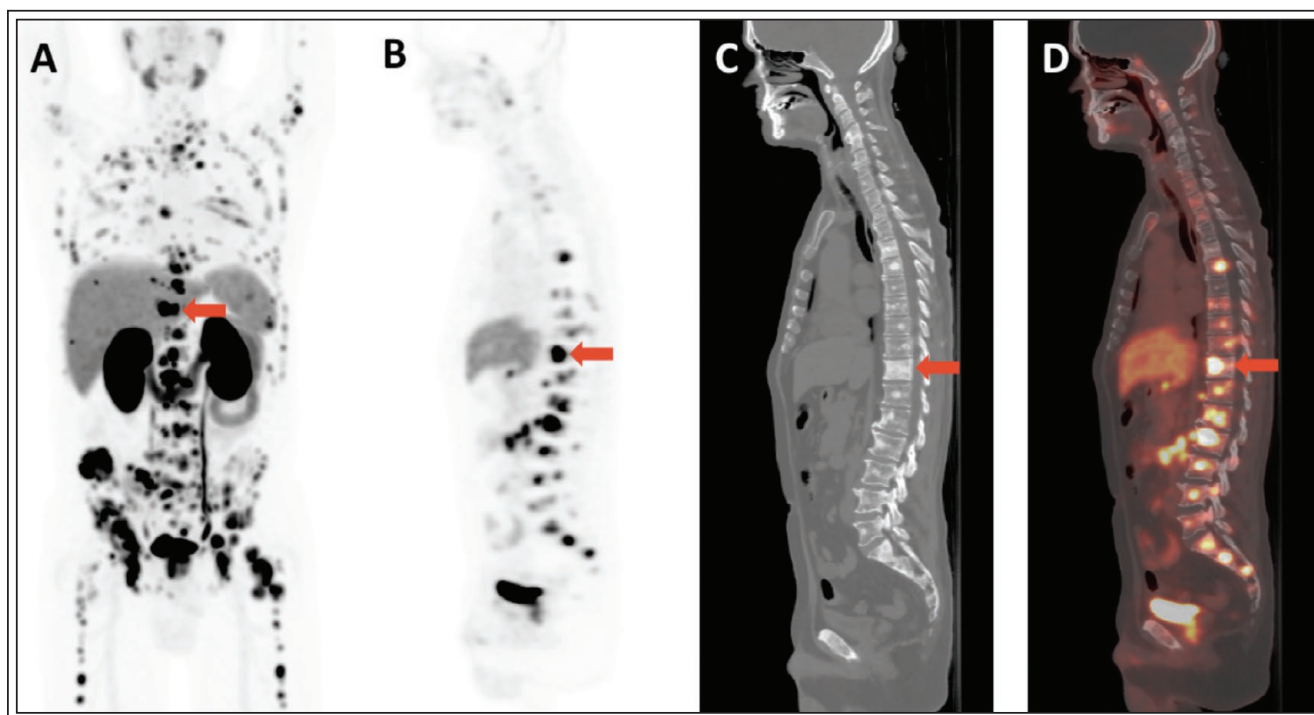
59-year-old man with widespread metastatic castration-resistant prostate cancer and PSA of 57 who presented for evaluation for treatment with PSMA-targeted radioligand therapy. (A) Maximum intensity projection (MIP) from ^{18}F -DCFPyL PET and corresponding (B) sagittal PET, (C) CT, and (D) PET/CT images show extensive bone metastatic disease (example lesion indicated by arrow).
